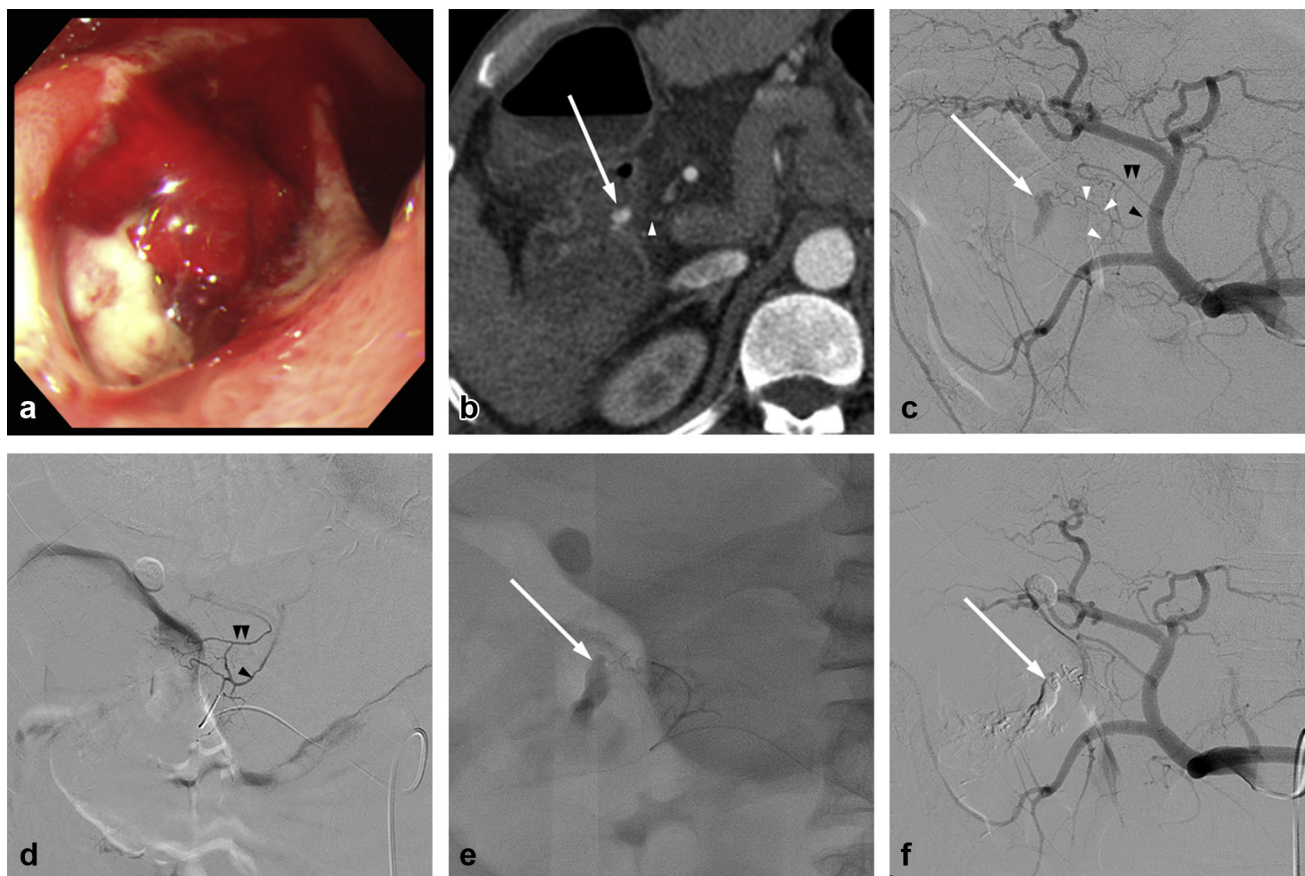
A 61-year-old man presented with acute hematochezia and tachycardia. (a) A large ulcer with active bleeding was seen at the duodenal bulb on endoscopic examination. The endoscopist recommended immediate angiography. (b) Contrast-enhanced CT showed a pseudoaneurysm (white arrow) at the medial wall of the duodenal bulb. A fine arterial channel (white arrowhead) was suspected to be connected to the pseudoaneurysm. (c) Celiac angiography revealed contrast media extravasating (white arrow) from a fine feeding artery (white arrowheads) arising from the gastroduodenal artery. This artery formed an arterial network that was connected to the common hepatic artery via 2 channels (black arrowhead, double black arrowhead). (d) The hemodynamic change caused by engagement of the microcatheter into the feeding branch from the gastroduodenal artery resulted in flow of the contrast media injected via the microcatheter into the common hepatic artery via the 2 channels (black arrowhead, double black arrowhead) without filling the pseudoaneurysm. (e) After the tip of the microcatheter was advanced closer to the bleeding point, the NBCA and ethiodized oil mixture could fill the pseudoaneurysm (white arrow) without overflowing into the common hepatic artery. (f) Completion angiography revealed that successful embolization of the extravasating point and the feeding artery was achieved with a glue cast (white arrow), and the common hepatic artery and gastroduodenal artery were intact.
